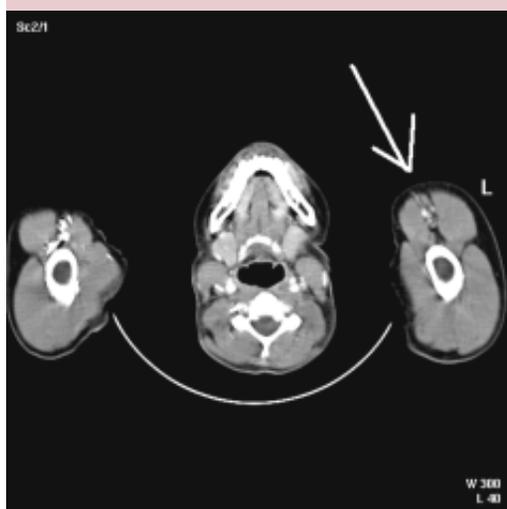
CT scan of 23-years-old woman with thrombosis of left brahiocephalic trunk (oedema of left upper extremity – see white arrow)
